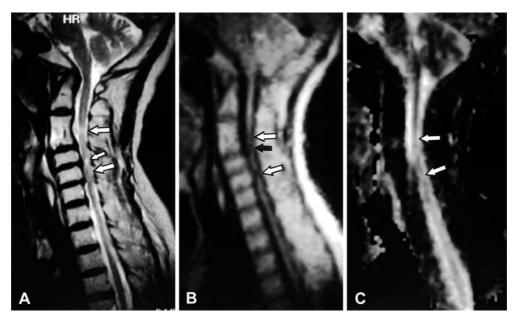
Myelomalacia in a 67-year-old woman 3 years after decompressive surgery for the canal stenosis due mainly to ossification of the posterior longitudinal ligament at C3–6, most prominent at C3–4. A A T2-weighted image shows C3–4 anterior fusion and high signal indicating myelomalacia at C3–4 and C5–6 (*large arrows*). B DWI with diffusion gradients (b 400 s/mm²) applied in the craniocaudal direction shows that the lesions of myelomalacia give low signal (*white arrows*). C This is confirmed as due to increased diffusion on the ADC map (*arrows*). Little improvement after surgery may partly be due to residual stenosis at C5–6, but the myelomalacia at C3–4, more extensive than at C5–6 was thought to be the main cause. Low signal at the C4–5 level (B, *black arrow*) may be partial-volume artefact. The high-signal area at C5–6 in A (small arrow), possibly representing recent vasogenic oedema, does not give low signal on DWI
